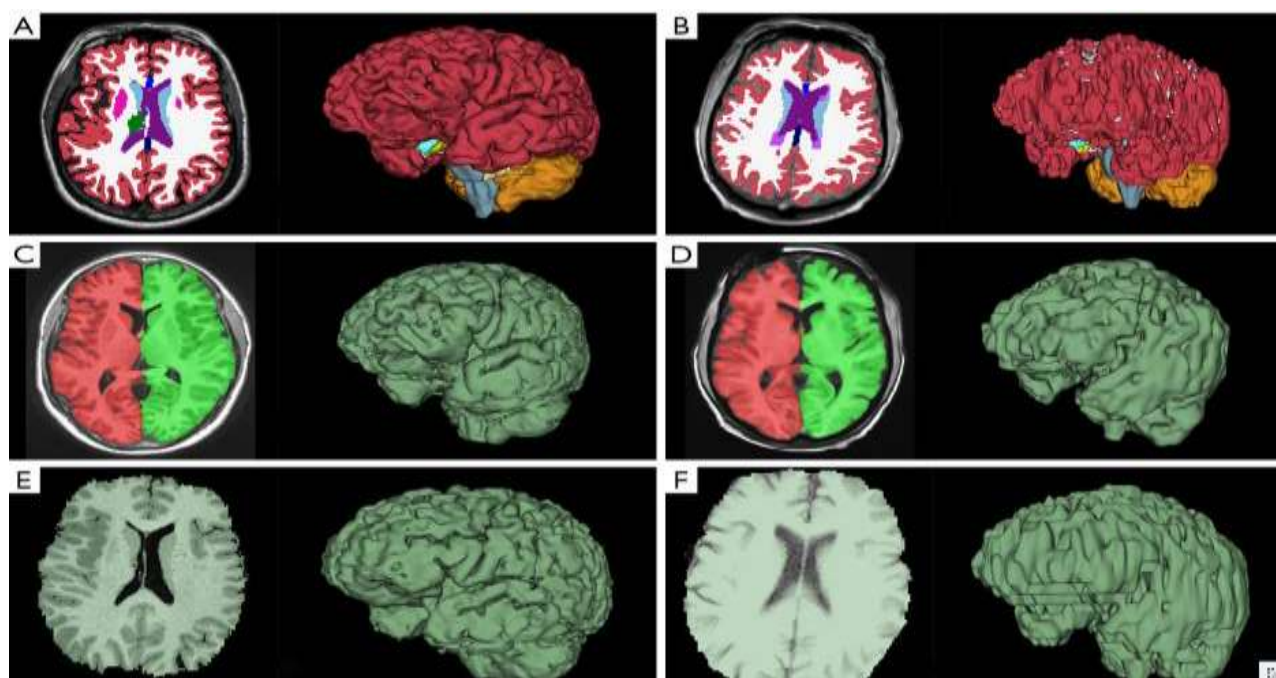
Examples of BV segmentations. (A) FreeSurfer BV using 3D T1 MRI. (B) FreeSurfer BV using 2D T1 MRI. (C) volBrain BV using 3D T1 MRI. (D) volBrain BV using 2D T1 MRI. (E) 3D Slicer BV using 3D T1 MRI. (F) 3D Slicer BV using 2D T1 MRI. The (A,C,E) segmentations and (B,D,F) segmentations are derived from two different subjects. BV, brain volume; MRI, magnetic resonance imaging [41].
